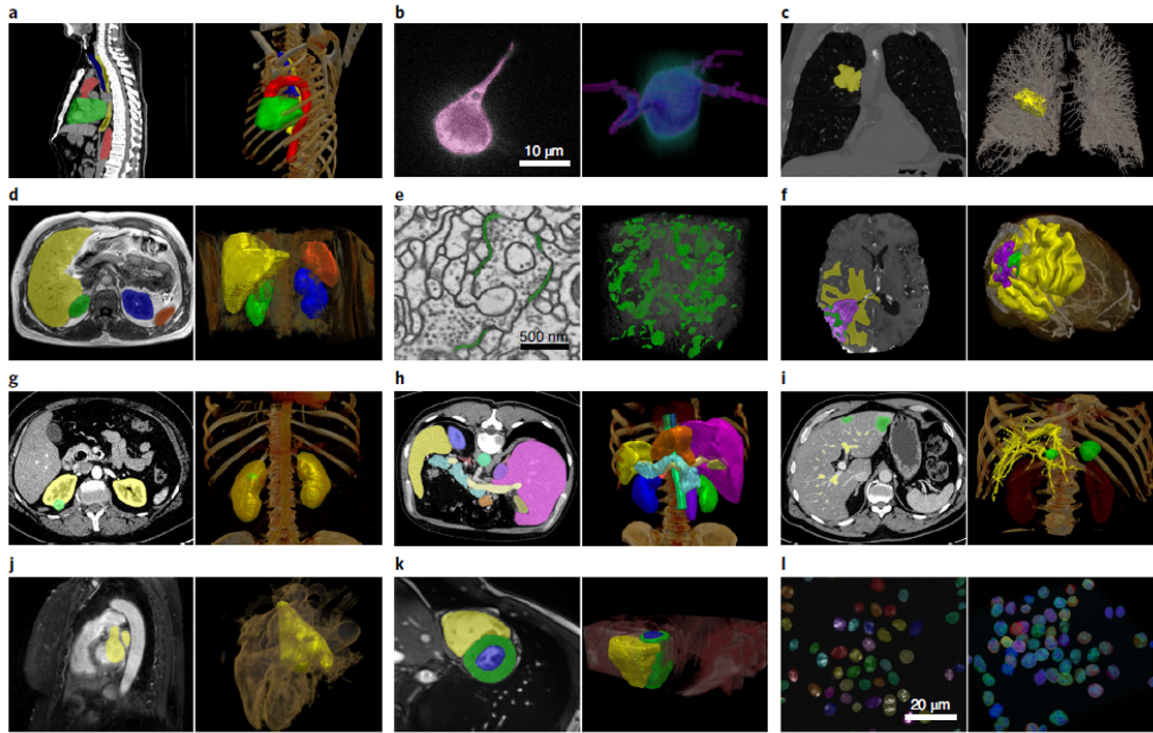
A set of medical images segmented by the nnU-Net. Target structures for each dataset are shown in 2D projection (left) and in 3D (right). (a) Heart (green), aorta (red), trachea (blue) and esophagus (yellow) in CT images (dataset D18); (b) A549 lung cancer cells (purple) in FM (D22); (c) Lung nodules (yellow) in CT images (D6); (d) Liver (yellow), spleen (orange), left and right kidneys (blue and green, respectively) in T1 in phase MRI (D16); (e) Synaptic clefts (green) in EM scans (D19); (f) Edema (yellow), enhancing tumor (purple), necrosis (green) in MRI (T1, T1 with contrast agent, T2, FLAIR) (D1); (g) Kidneys (yellow) and kidney tumors (green) in CT images (D17); (h) Thirteen abdominal organs in CT images (D11); (i) Hepatic vessels (yellow) and liver tumors (green) in CT (D8); (j) Left ventricle (yellow) in MRI (D2); (k) Right ventricle (yellow), left ventricular cavity (blue) and myocardium of left ventricle (green) in cine MRI (D13); (l) HL60 cell nuclei in FM (D21) [8].
